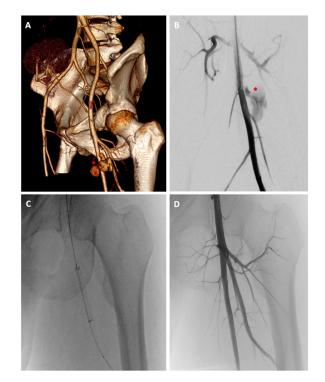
Panel A*, preoperative CT-scan (volume rendering); *Panel B*, selective angiogram of deep femoral artery (*pseudoaneurysm); *Panel C*, covered stent graft deployment across the pseudoaneurysm's neck; *Panel C*, final angiogram showing the complete exclusion of the pseudoaneurysm and patency of deep femoral artery.
